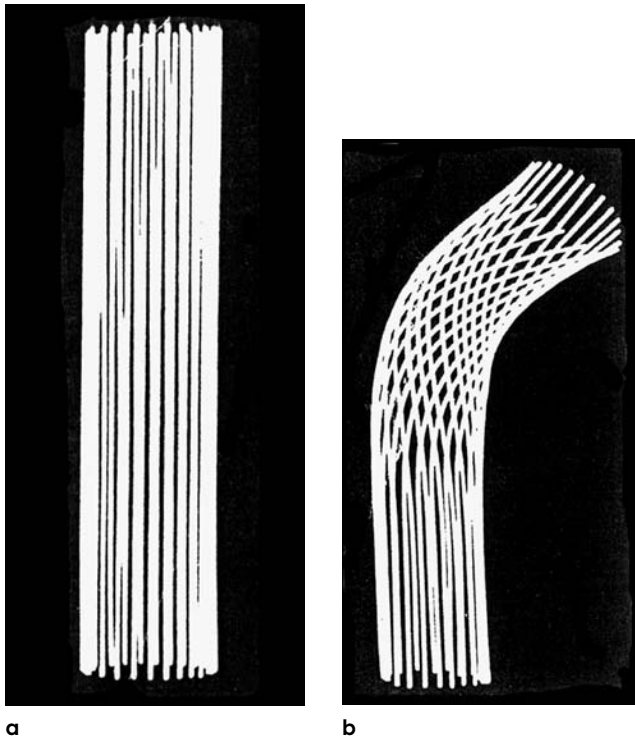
Radiograph of a cylinder composed of parallel wires.
